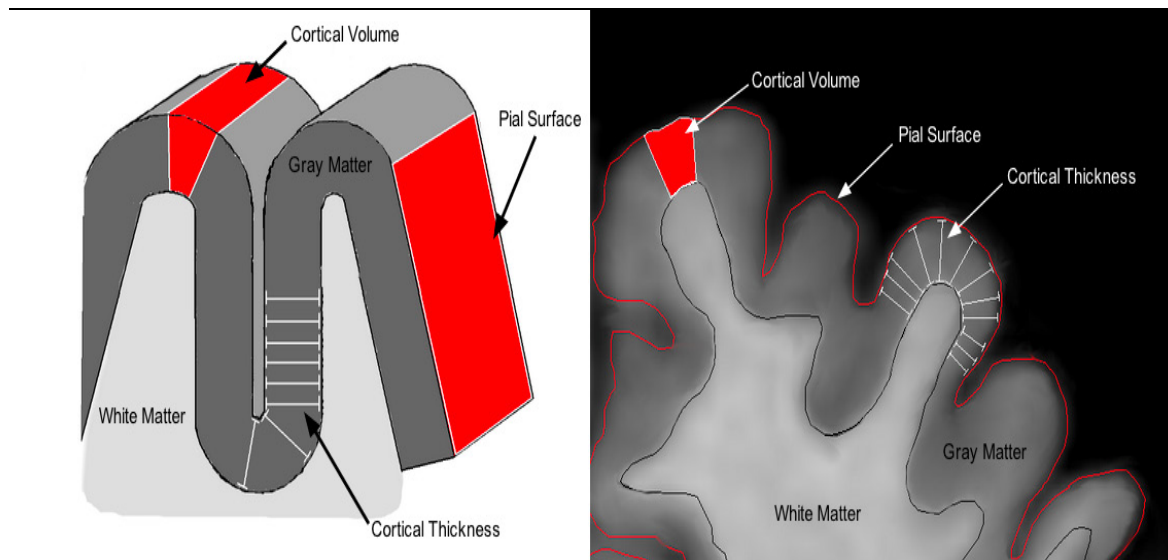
Neuroanatomic Relationship of CV, CT, PSA. Figure created by Trevor Huff
